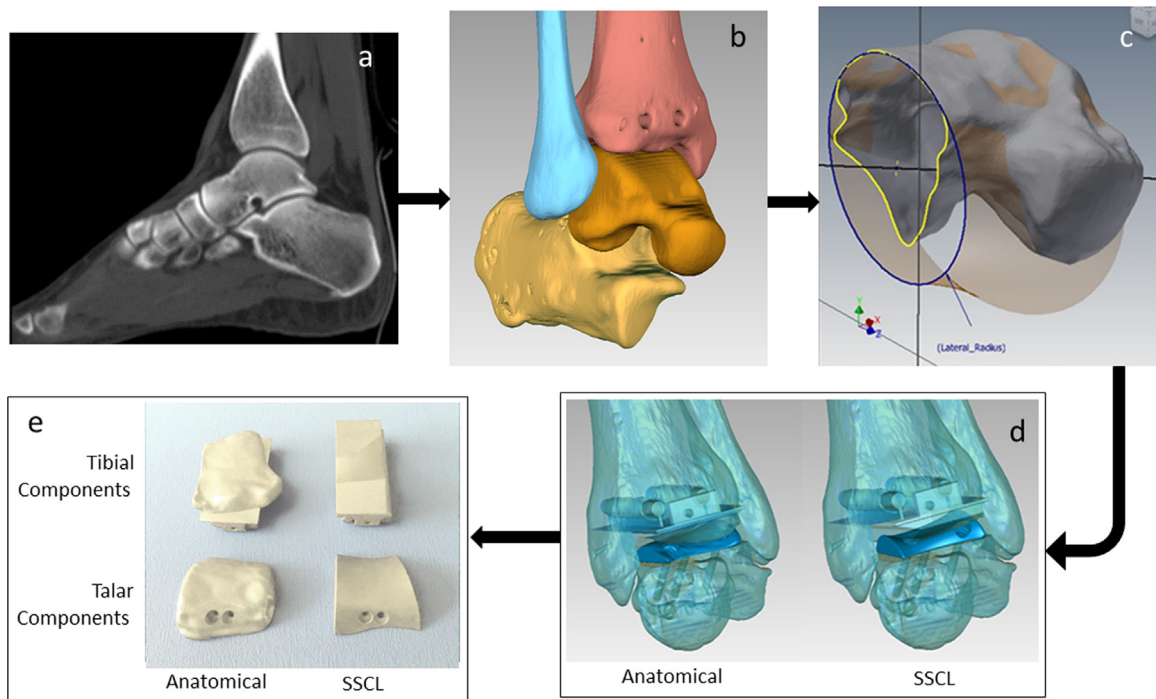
Images for the process from CT imaging to 3D printed surface sets: a – CT slice image showing the bones to be segmented; b – 3D rendering of the four relevant bones, front view; c – one of the measurements performed on the talar bone model, to produce the skewed truncated cone with the apex of the cone oriented laterally (SSCL) surface approximation; d – 3D rendering of the talar and tibial components of the anatomical (left) and SSCL (right) surfaces once implanted in the corresponding bones; e – view of the 3D printed implant sets: the anatomical (left) and SSCL (right).
